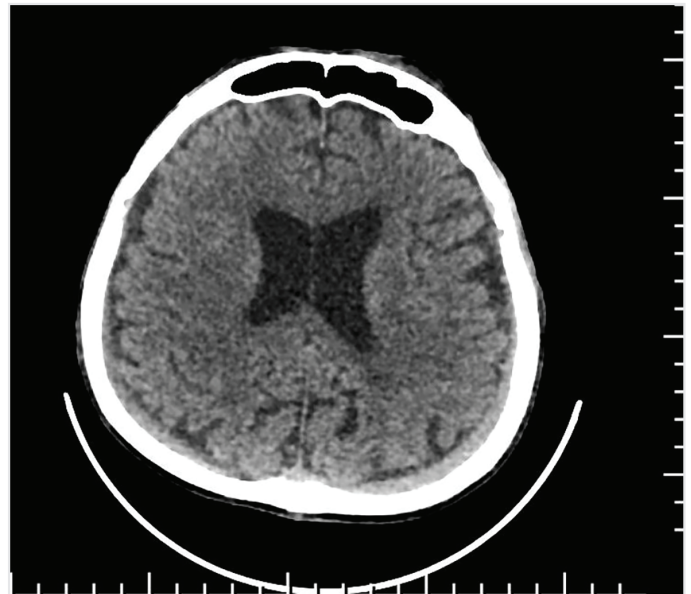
Axial computed tomography imaging in the parenchymal window 1 month after the second surgery. It is observed that the subdural collection and air densities regressed
